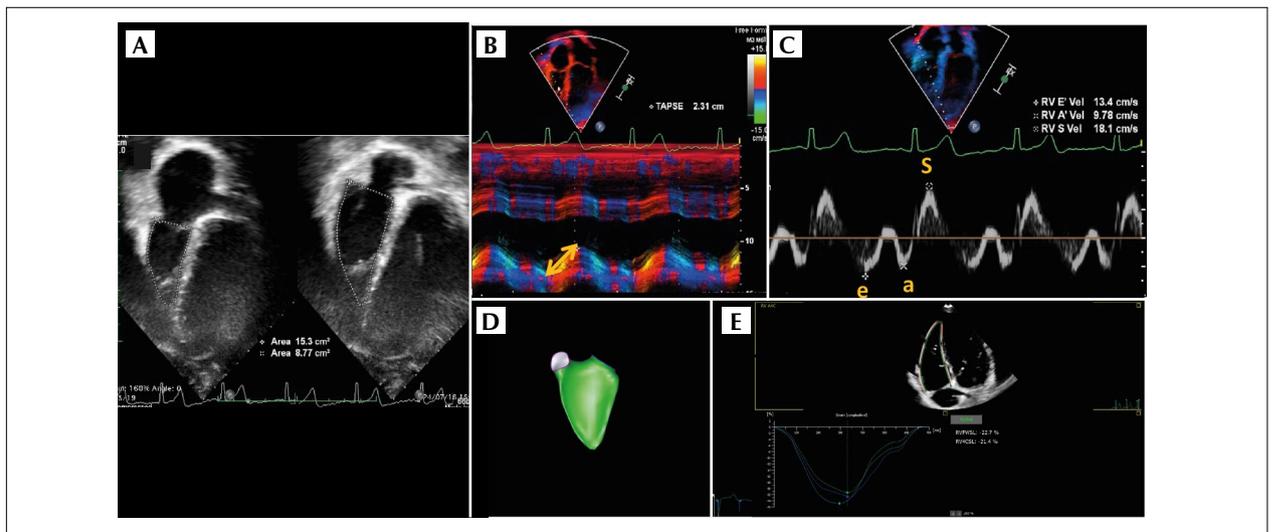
Right ventricular (RV) systolic function assessment. (A) RV fraction area change. (B) Tricuspid annular plane systolic excursion. (C) Tissue Doppler showing tricuspid annulus velocities on the lateral wall of the left ventricle. (D) Three-dimensional analysis of RV volumes and ejection fraction. (E) Apical four-chamber plane focusing on the RV for calculation of the RV global longitudinal strain.
